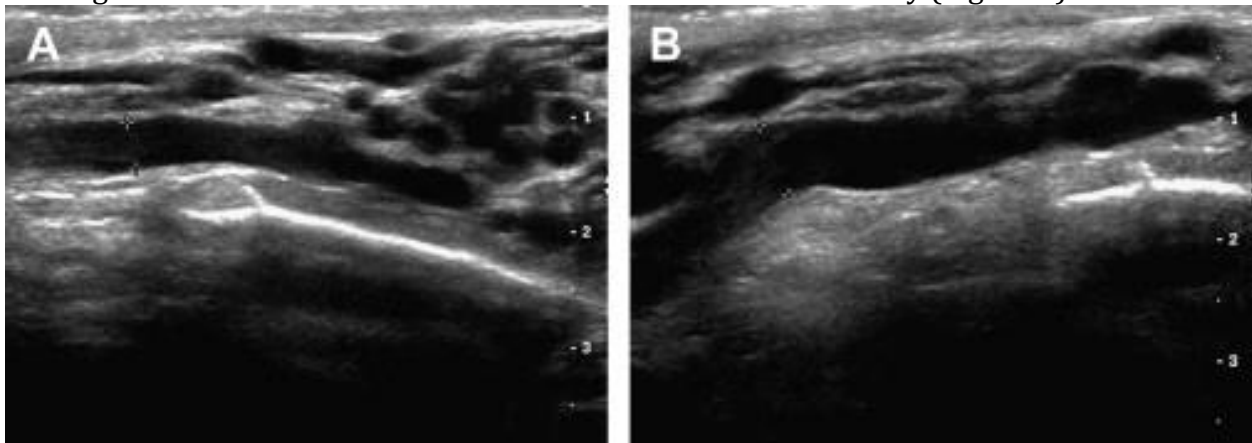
Ultrasound images are normal in B-mode: initial echogram (A) and after Valsalva test (B).
